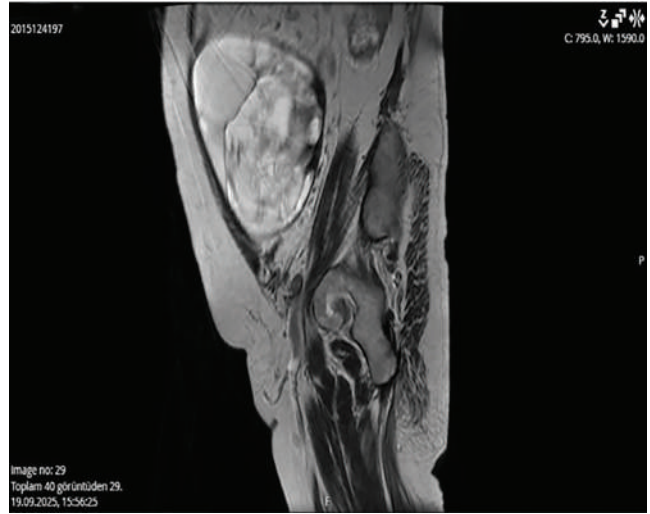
Pelvic MRI showing a solid-cystic, septated giant mass.
